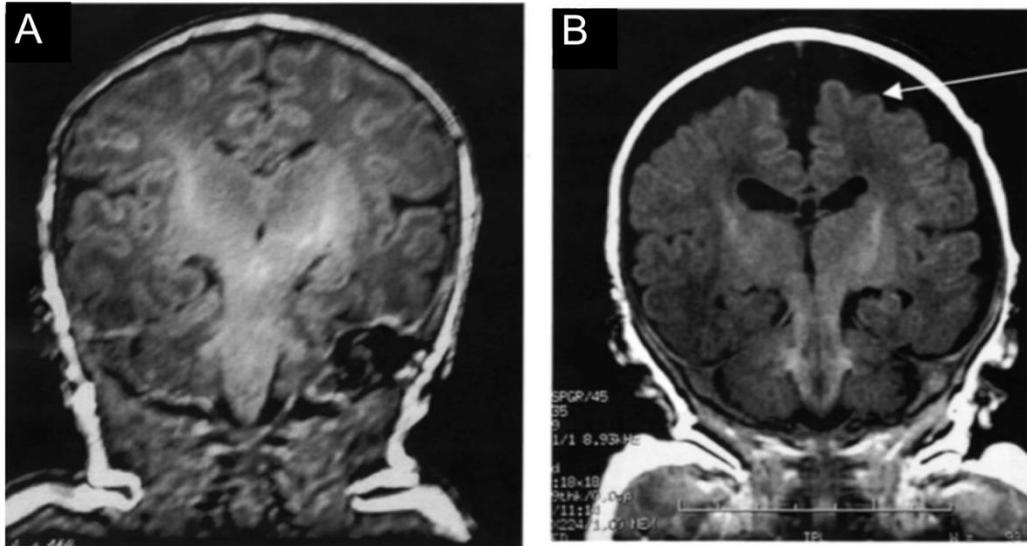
Comparison of magnetic resonance images both obtained at term equivalent of A) an infant born at 30 weeks gestation and B) an infant born at 23 weeks' gestational age with evidence of moderate ventriculomegaly with markedly enlarged subarachnoid spaces (arrow), diffuse white matter loss and immature gyration. Note. Figure adapted from (Inder et al., 2003).
